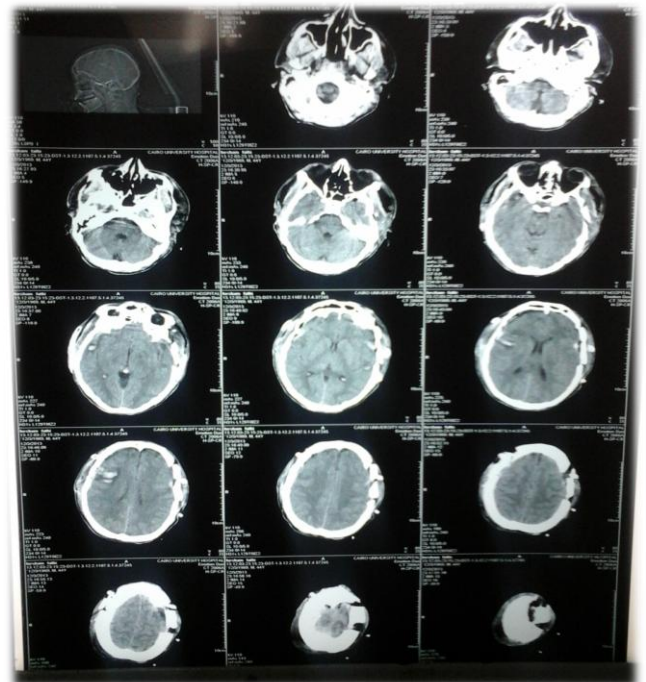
CT brain of case no (4) after the second operation
